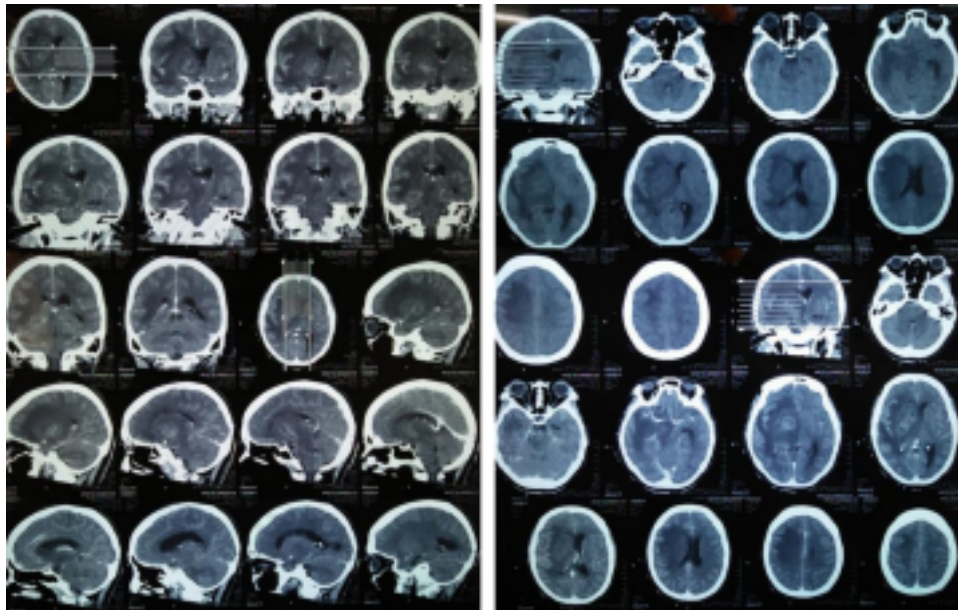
Head CT on presentation
